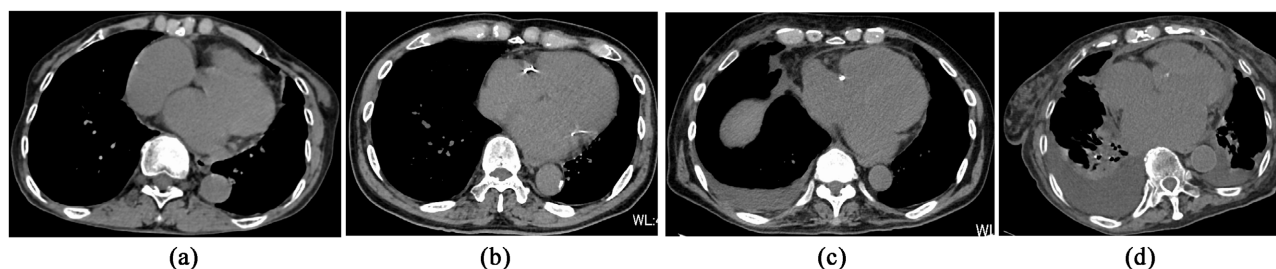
Postoperative chest computed tomography reveals improved dilatation of the right atrium in all cases ((a) case 1, (b) case 2, (c) case 3, and (d) case 4).
